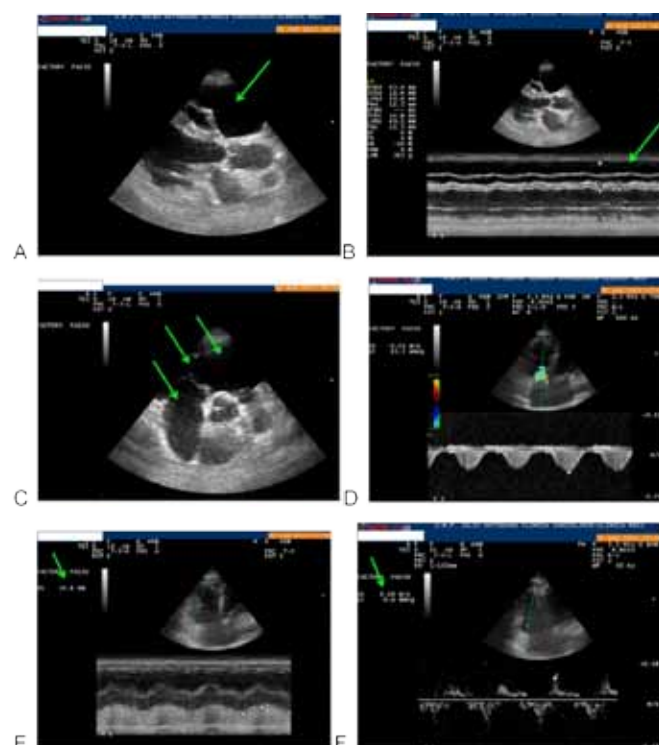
(A) Echocardiographic image in the parasternal long axis view showing dilation of the right ventricle in two-dimensional mode, (B) in M-mode, (C) parasternal short axis at the level of great arteries showing, right atrial, right ventricular and right ventricular outflow tract dilation, (D) apical four chambers: tricuspid regurgitation in the Doppler view, (E) apical 4 chambers showing reduced right ventricular function with low TAPSE at the lateral free wall tricuspid annulus, and (F) reduced right ventricular function demonstrated by reduced amplitude of the S wave in tissue Doppler imaging.
